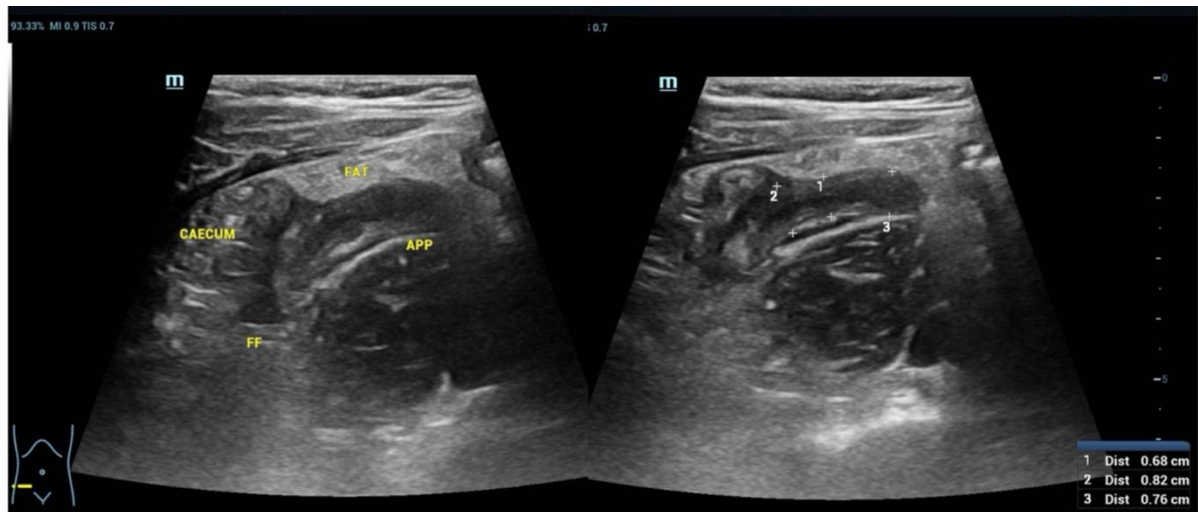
Formal ultrasound image of a dilated, noncompressible appendix (0.8 cm) with echogenic fat stranding and minimal peripendiceal fluid.
